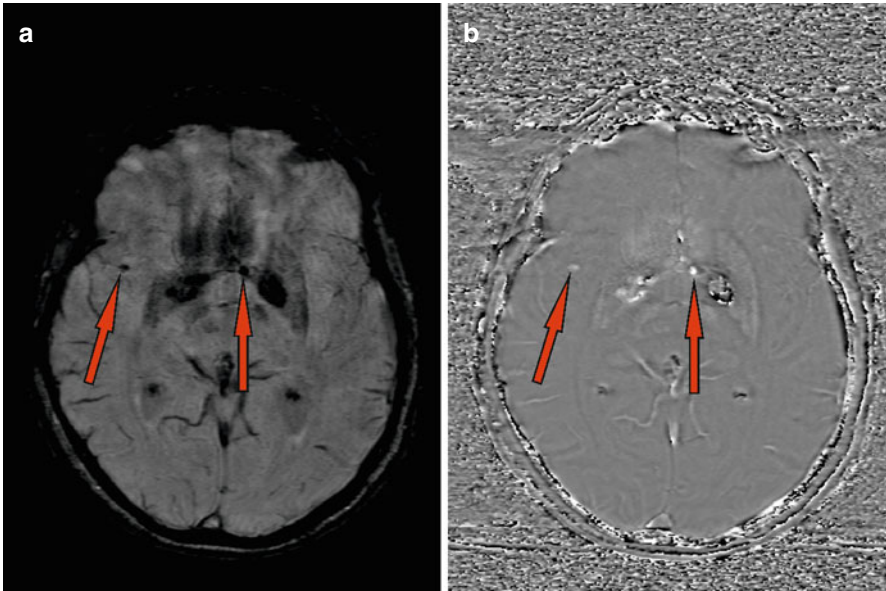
Brain MRI of two microbleeding foci (a) SWI sequence (red arrows) with corresponding MRI SWI-Pha sequence (b)
